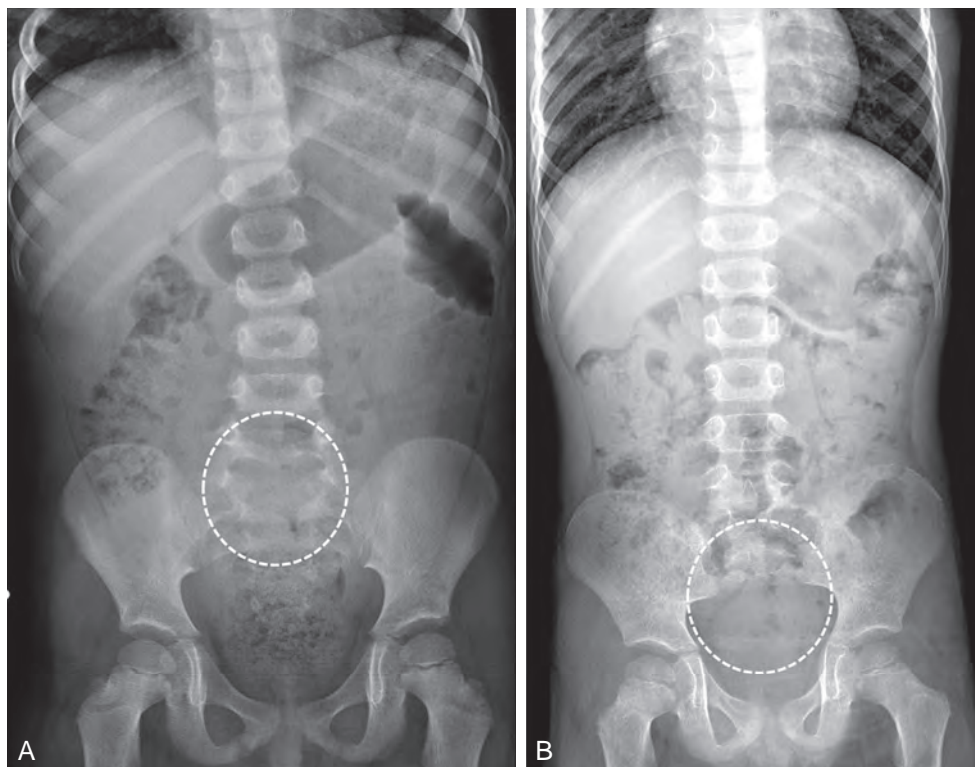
Bony abnormalities detected on abdominal radiograph during assessment of difficult-to-treat constipation. A, Lumbar bony defects consistent with occult spinal dysraphism. B, Absent sacrum, suggestive of sacral agenesis.
